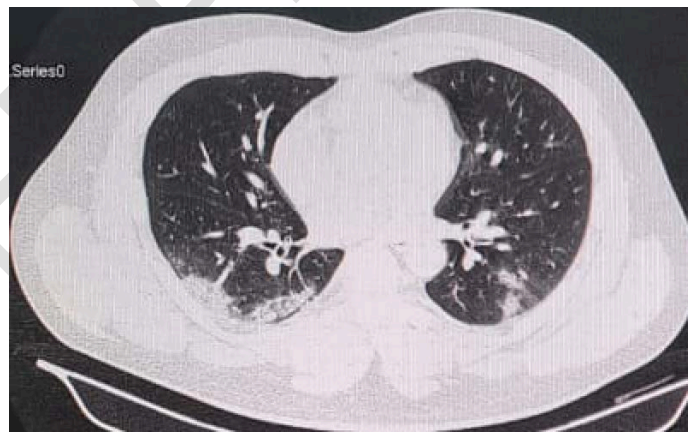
Axial slice CT-scan without contrast at admission showed bilateral multifocal ground-glass opacity
